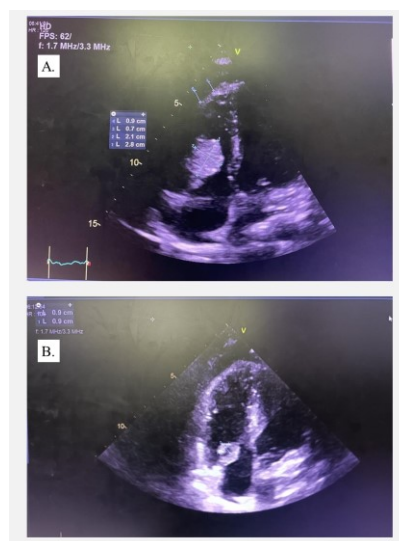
A. Transthoracic Echocardiography show vegetation in Tricuspid Valve 21mm x 28mm ; B. Transthoracic Echocardiography show vegetation in Tricuspid Valve 9mm x 9mm.
